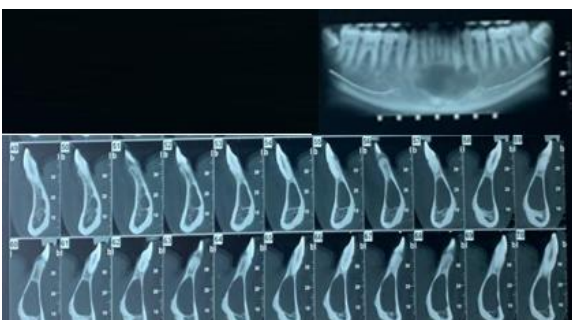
A cone beam shows an isolated, round, unilocular hypodense lesion in the antero inferior region.
